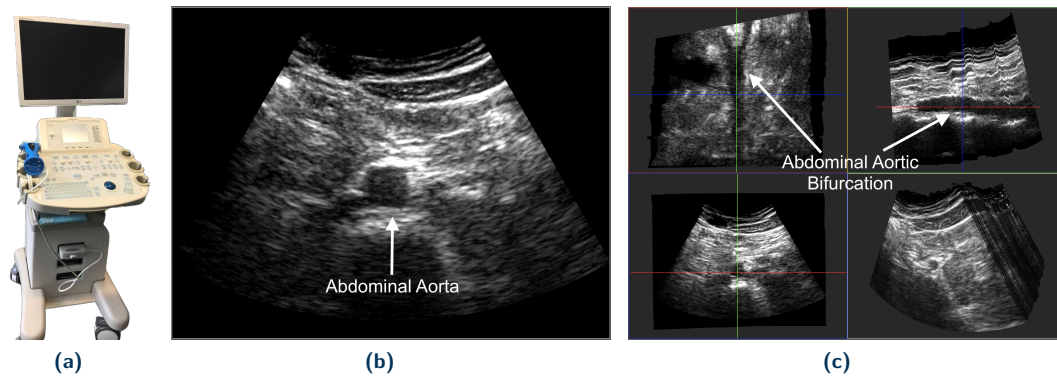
The Ultrasound imaging modality with exemplary images. (a) An ultrasound device used for preoperative/intraoperative imaging, (b) A 2D cross-sectional ultrasound image of the abdominal aorta, and (c) Robotically tracked 2D ultrasound images compounded into a 3D volume, displaying three anatomical planes and the abdominal aortic bifurcation.
